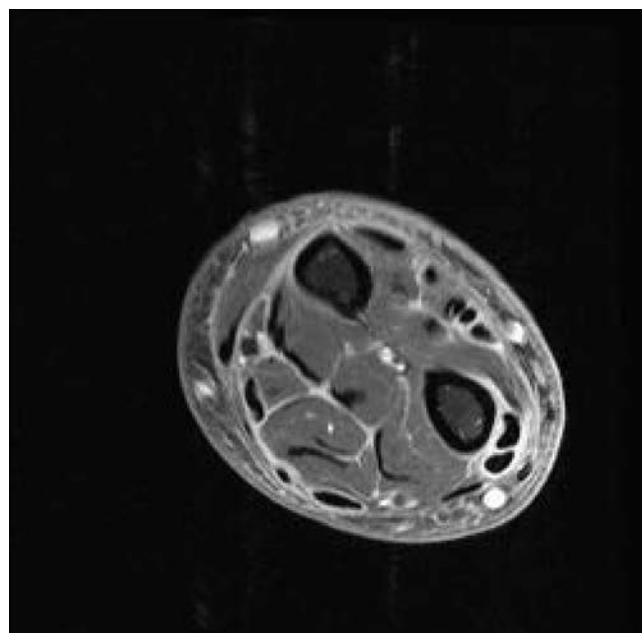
Magnetic resonance imaging with contrast forearm: enhanced fascia surrounding muscles
